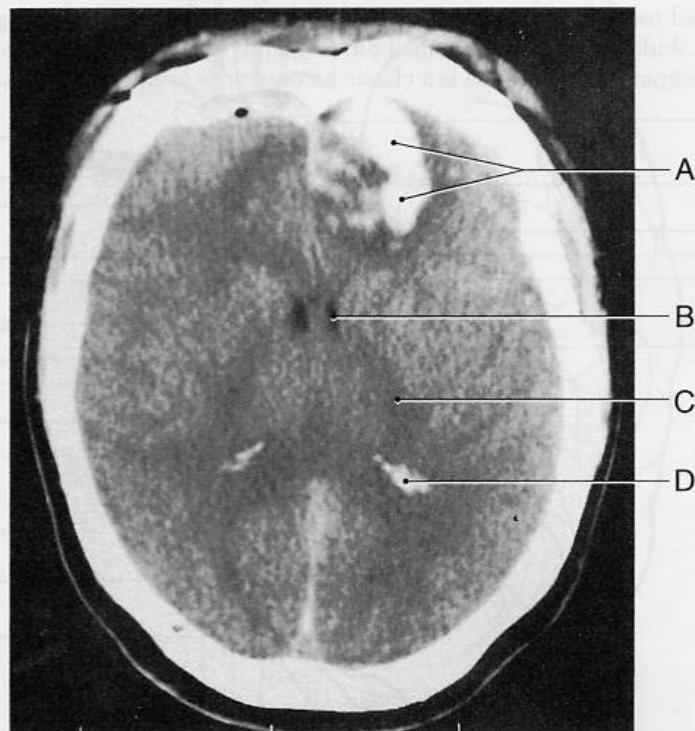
Computed tomography scan axial section showing an intraparenchymal hemorrhage in the left frontal lobe. (A) Intraparenchymal hemorrhage; (B) lateral ventricle; (C) internal capsule; (D) calcified glomus in the trigone region of the lateral ventricle.
